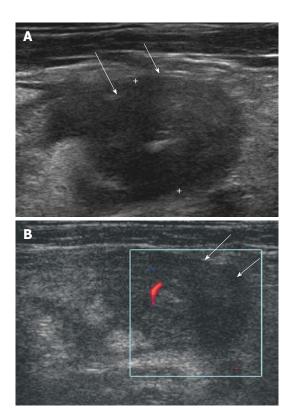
Isolated Crohn's appendicitis. A: Marked thickening with transmural hypoechoic echo-alteration of appendiceal wall (arrows); B: Mild increased blood flow in thickened appendiceal wall (arrows) was seen on color Doppler study.
